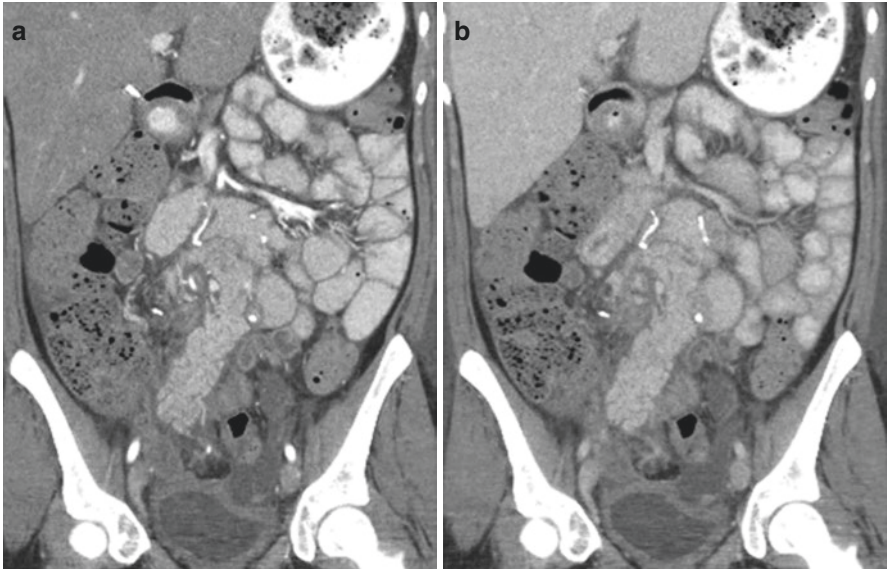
Coronal reformatted contrast-enhanced CT of the pancreas transplant. There is small amount of fluid surrounding the pancreas (arrows)
